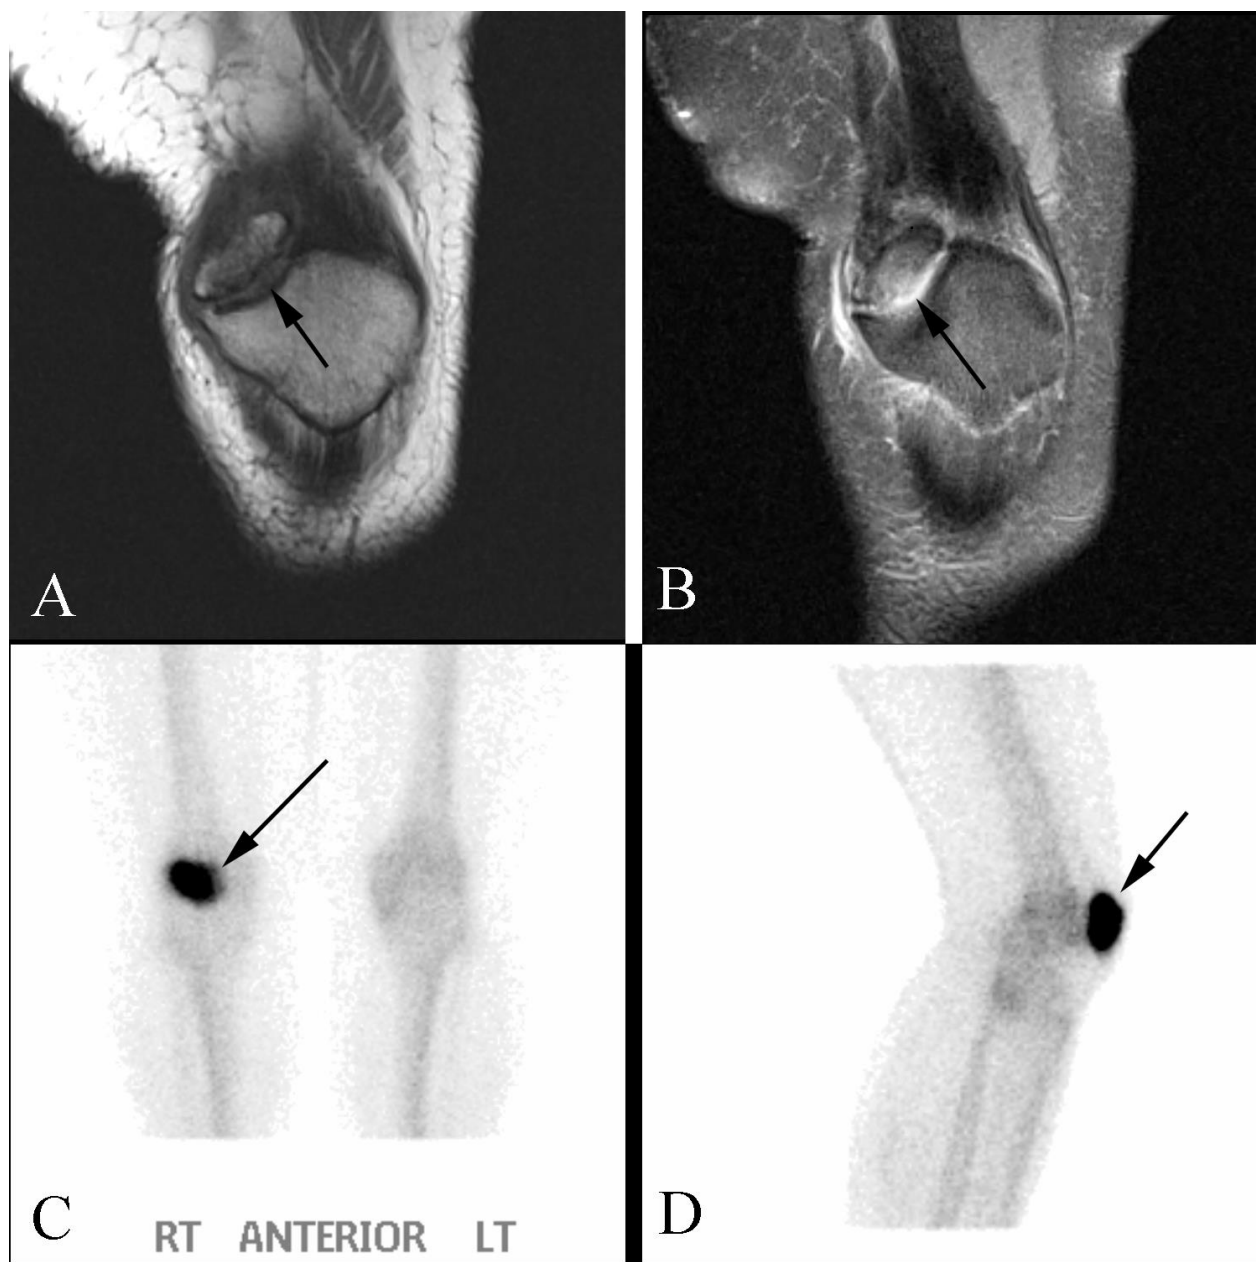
Symptomatic bipartite patella in a 41 year old woman with chronic knee pain. A. Coronal T1 weighted MR image demonstrates a cleavage plane between the body of the patella and a superolateral ossification center (arrow). Such an appearance is a relatively frequently seen (and usually asymptomatic) normal variation. B. Coronal fat-suppressed proton density image demonstrates increased signal intensity (arrow) along the interface between the patella and accessory ossification center. In asymptomatic patients, this interface will demonstrate *decreased*, not *increased* (as in this case), signal intensity. C. Frontal view nuclear medicine bone scan shows intense increased radiotracer uptake of the patella (arrow). D. Lateral view nuclear medicine bone scan confirms that the intense activity is in the patella (arrow) and not in the underlying femur.
